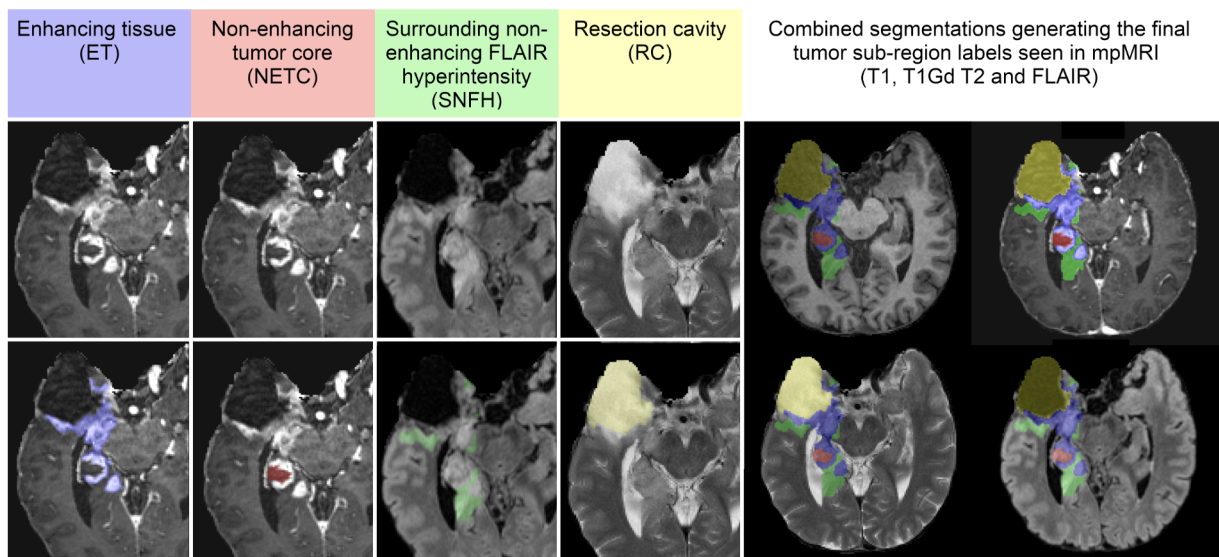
Multi-Compartment Glioma Segmentation in Post-Treatment MRI Scans
